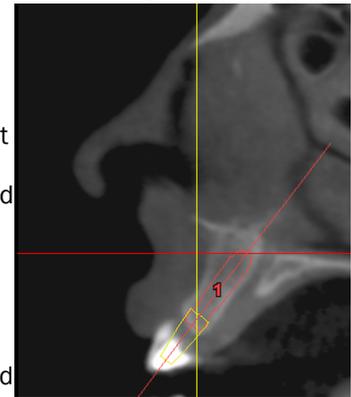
The use of CT scan is instrumental in determining the amount of bone available for implants placement.
